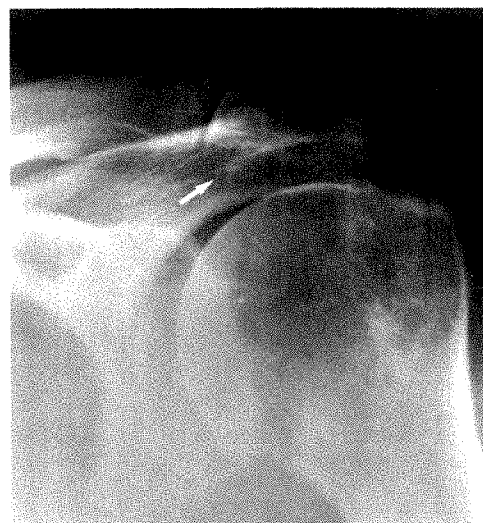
Conventional anteroposterior radiograph shows a subacromial spur on anterior-inferior margin of acromion (arrow). Sclerosis of greater tuberosity is thought to be due to cuff degeneration.
